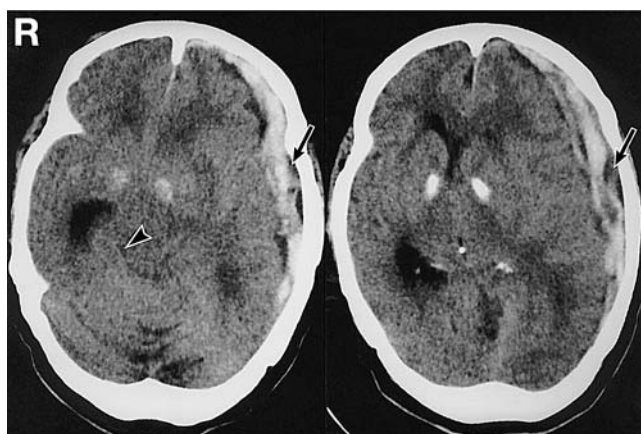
Computed tomography scans performed immediately after admission revealing a subdural hematoma over the entire left cerebral hemisphere with a thickness of approximately 1.5 cm. A low-density band (arrow) was present between the hematoma and the inner wall of the skull bone. Almost complete obliteration of the contralateral ambient cistern (arrowhead) was seen in addition to marked shift of the midline structures to the right.
